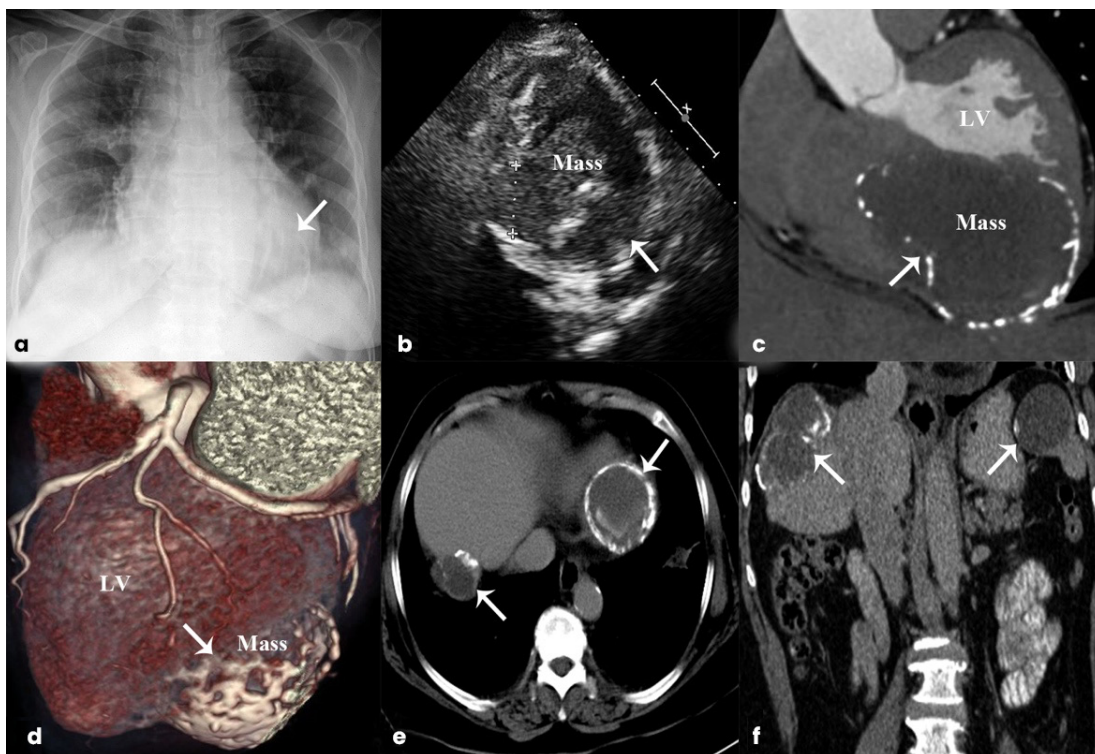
(a) Left heart border enlargement with eggshell-like calcification on chest X-ray. (b) Transthoracic echocardiography reveals a round, heterogeneous mass with patchy calcification in the left ventricle. (c, d) Contrast-enhanced CT reveals a 59 × 62 × 85 mm cystic mass with ring-like calcifications, primarily affecting the left ventricular inferior lateral wall and interventricular septum. (e, f) Non-enhanced abdominal CT demonstrates numerous cystic lesions with eggshell-like calcification within the liver and spleen.
